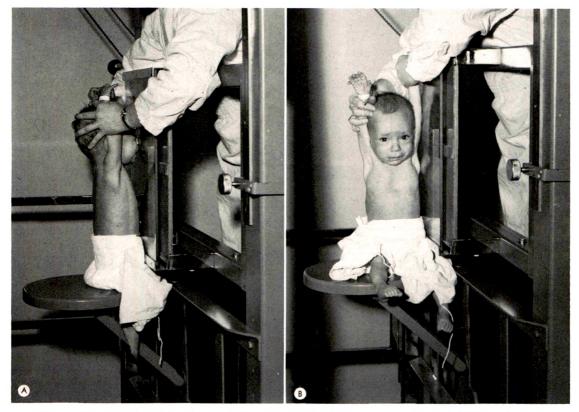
Photographs of the chest unit in use to obtain (A) posteroanterior and (B) lateral chest roentgenogram of an infant. Note how easily the technician can hold the patient in position.
